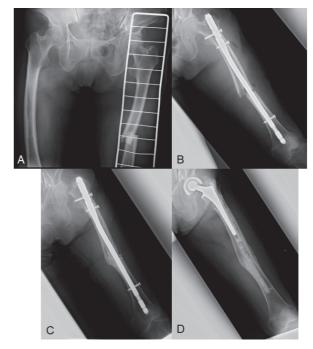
Case 1. A, Radiograph showing the left atypical femoral fracture (AFF). The right femoral bone had lateral bowing and localized periosteal thickening of the lateral cortex; B, Postoperative radiograph revealing valgus displacement; C, The displaced femoral neck fracture; D, Cemented hemiarthroplasty after the nailing's removal.
